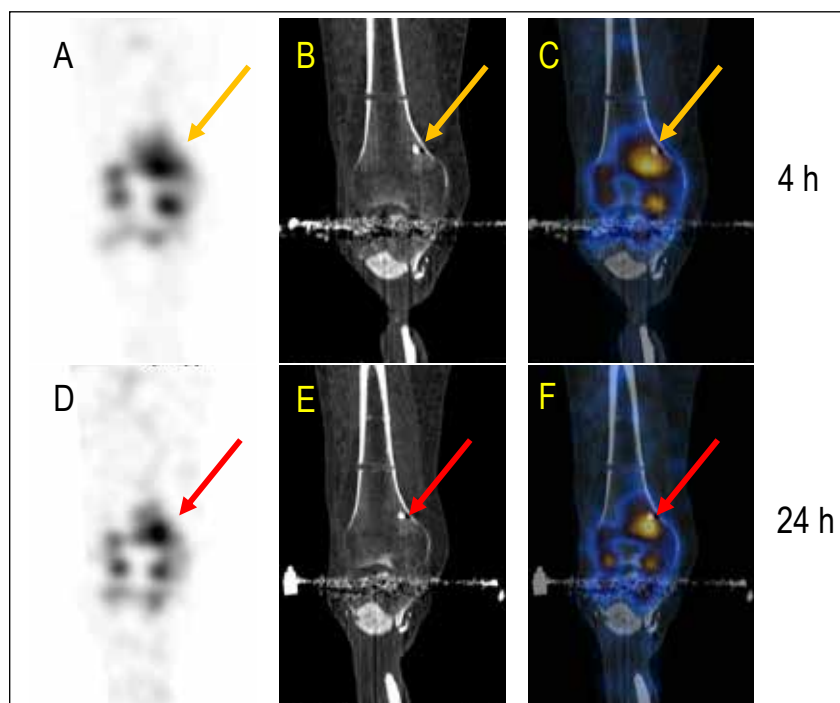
Anti-granulocyte antibody (AGA)-SPECT/CT presented an increased accumulation of granulocyte antibodies over time (orange arrows 4 h p.i., red arrows 24 h p.i.) in the medial femoral metadiaphysis adjacent to a radiopaque foreign body as an expression of an infected fragment. SPECT/CT with  $^{99m}\text{Tc}$ -labelled granulocyte antibodies in coronal views of SPECT (A,D), CT (B,E) and fused SPECT/CT (C,F).
